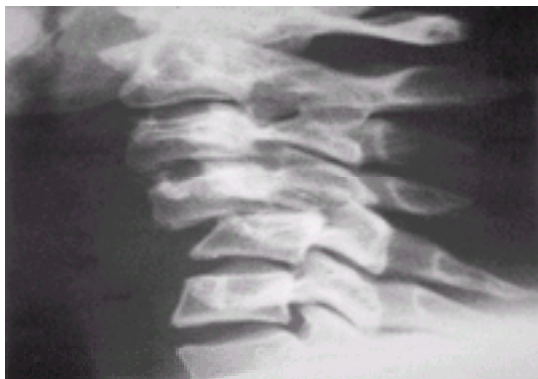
Lateral radiograph showing 50 per cent subluxation of C4 on C5, consistent with bilateral facet dislocation.
